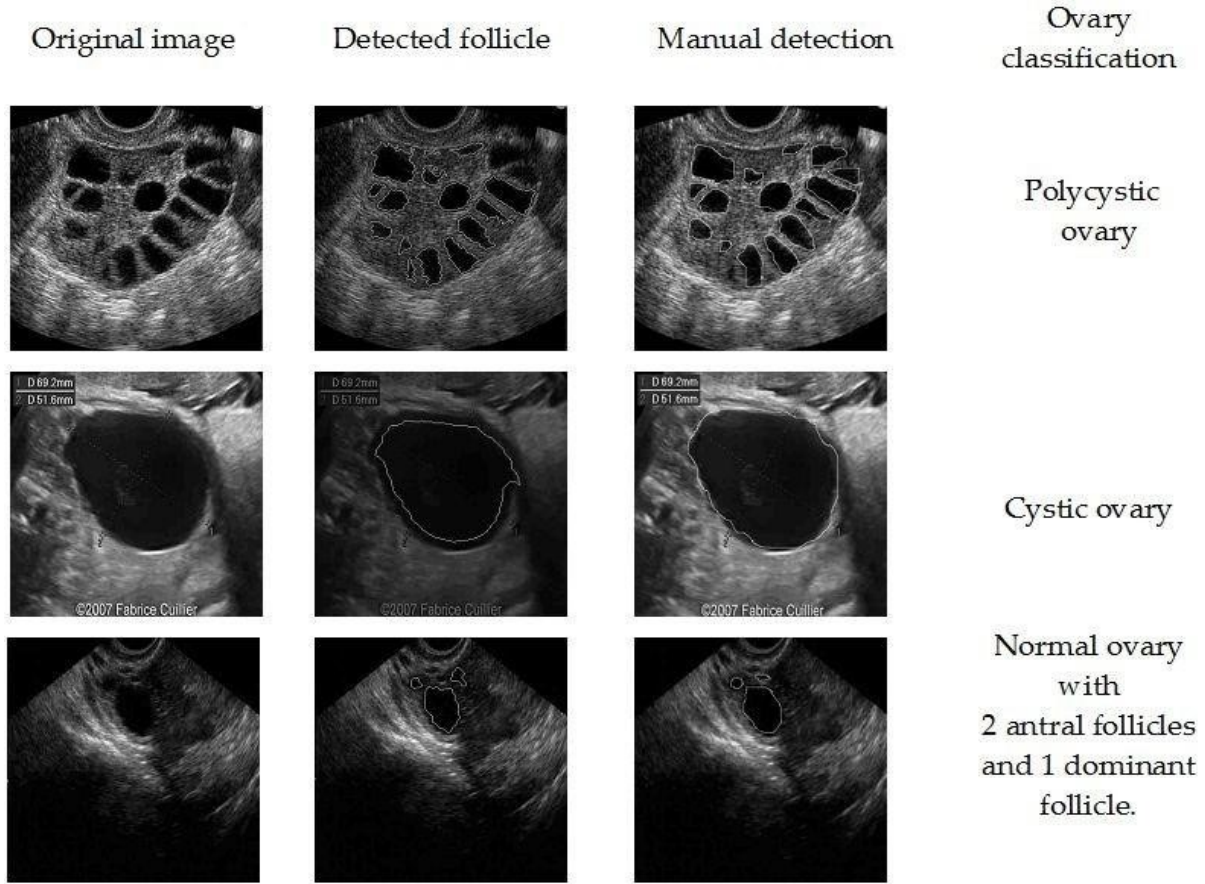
Automated and manual ultrasound follicle detection for ovarian classification. The figure compares original transvaginal ultrasound images, computer-detected follicles, and manual follicular segmentation used to classify ovaries as polycystic ovary, cystic ovary, and normal ovary with antral and dominant follicles.
